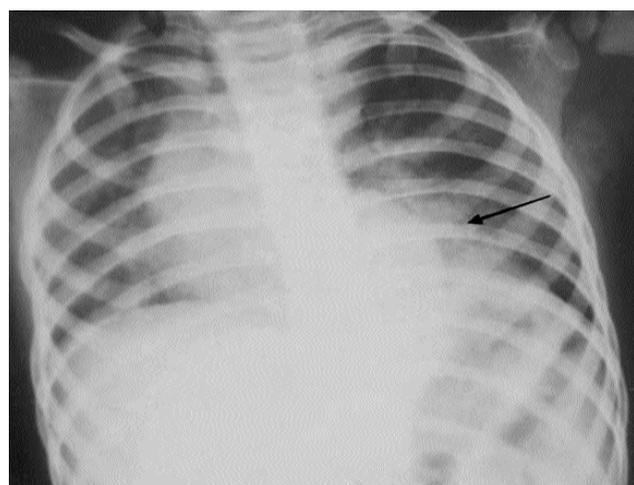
Chest X-ray PA view of patient showed a non homogenous retro cardiac opacity in left lower zone.
